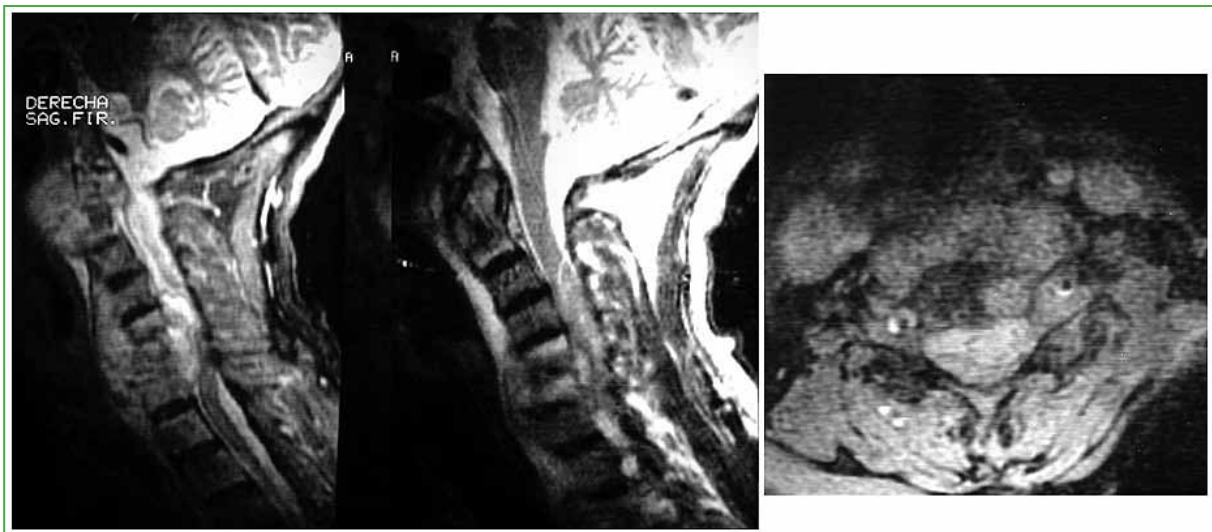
Case 17. MRI, T2-weighted sagittal sections without contrast and with contrast, and axial T2-weighted with contrast. Defined as C5-C7, A, C2, O2, + (Region: C5-C7, Location: anterior, Involvement: compresses the content, Association: disc and bone involvement, Perivertebral: positive - Anterior).
